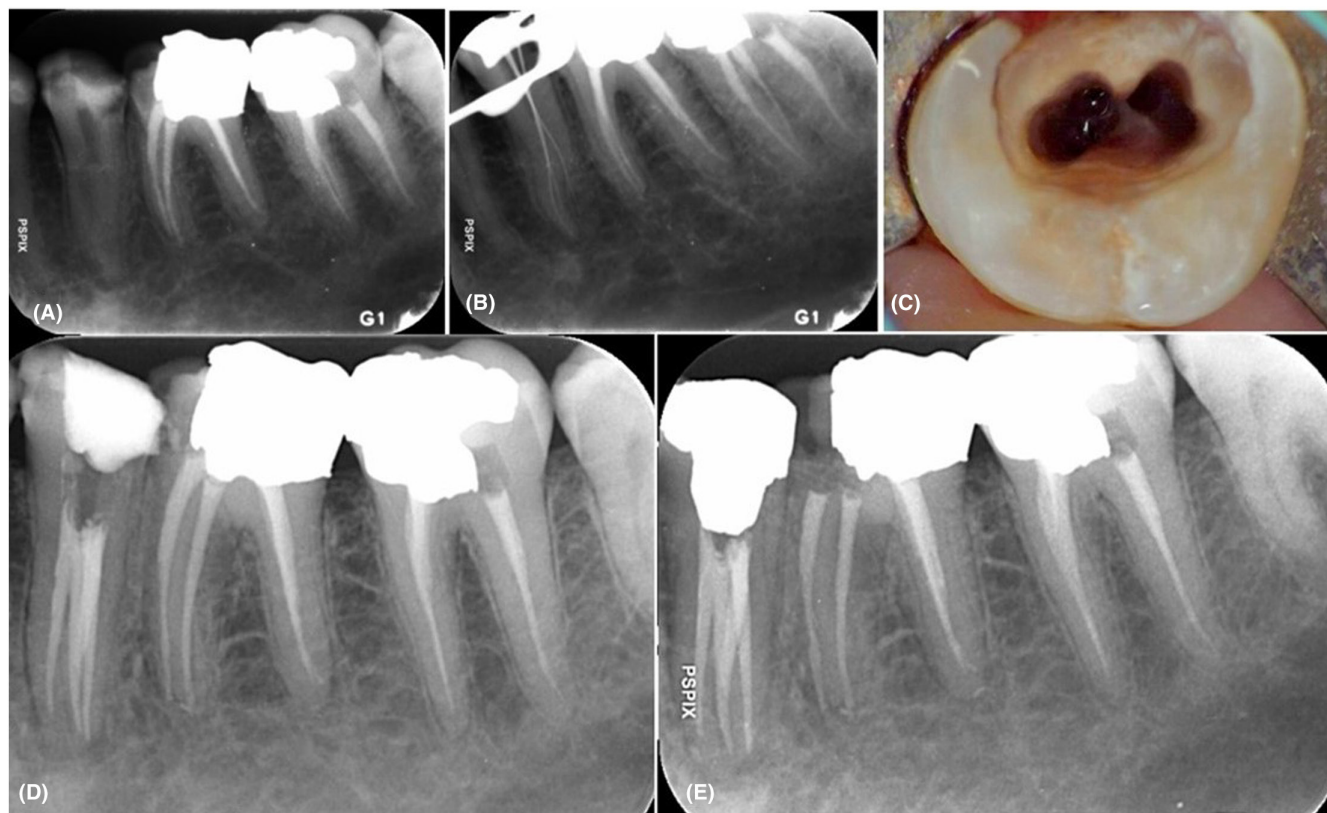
(A) Preoperative periapical radiograph. (B) Working length determination. (C) Four orifices were located in the middle third of the root. (D) Postoperative radiograph immediately after obturation (two canals are superimposed). (E) Six-month follow-up.
